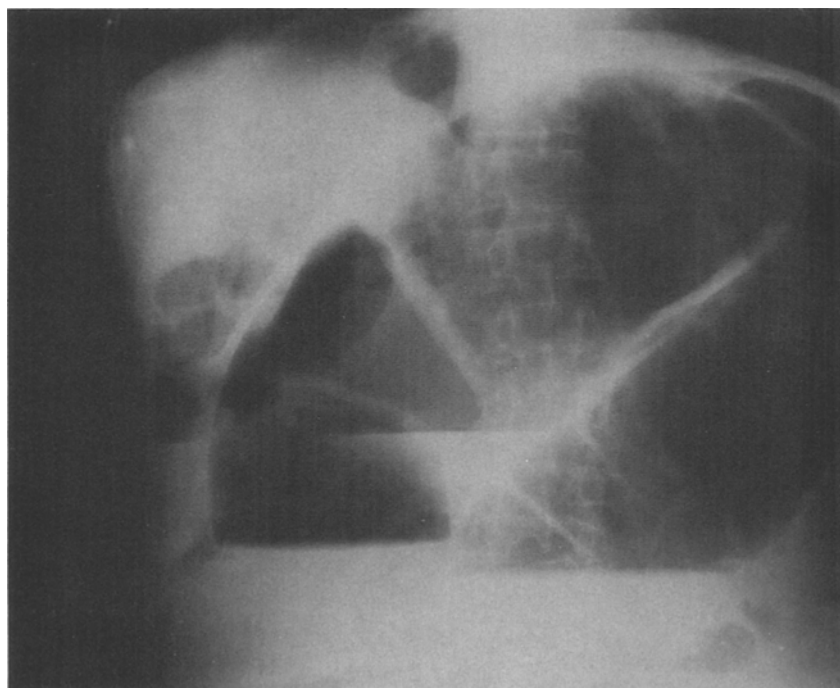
Erect plain x-ray of abdomen showing severely distended sigmoid loop with fluid levels.
